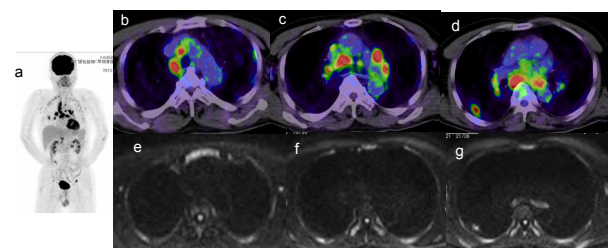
64 y.o. Male with Pulmonary Adenocarcinoma, but without Lymph Node Metastasis. Lymph nodes without metastasis were diagnosed correctly by DWI, not by PET-CT. The patient was diagnosed as n3 disease by PET-CT, but n0 disease by DWI. DWI showed lymph node station #2R as negative (e), lymph node stations #4R/#6 as negative (f) and lymph node stations #7/#10 as negative (g) (ADC 2.036 $\times 10^3$ mm²/sec) by DWI. The lymph nodes were diagnosed as pneumoconiosis pathologically
